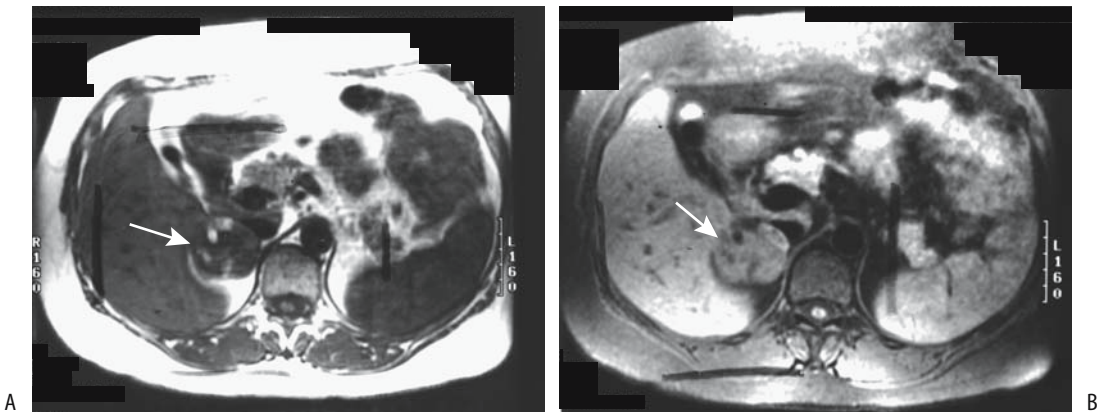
Adrenal myelipoma. A right adrenal tumor (arrows) contains foci which are hyperintense on T1- (A) and hypointense on T2-weighted images (B). (Source: Burgener FA, Meyers SP, Tan RK, Zaunbauer W. *Differential Diagnosis in Magnetic Resonance Imaging*. Stuttgart: Thieme, 2002, with permission.)
